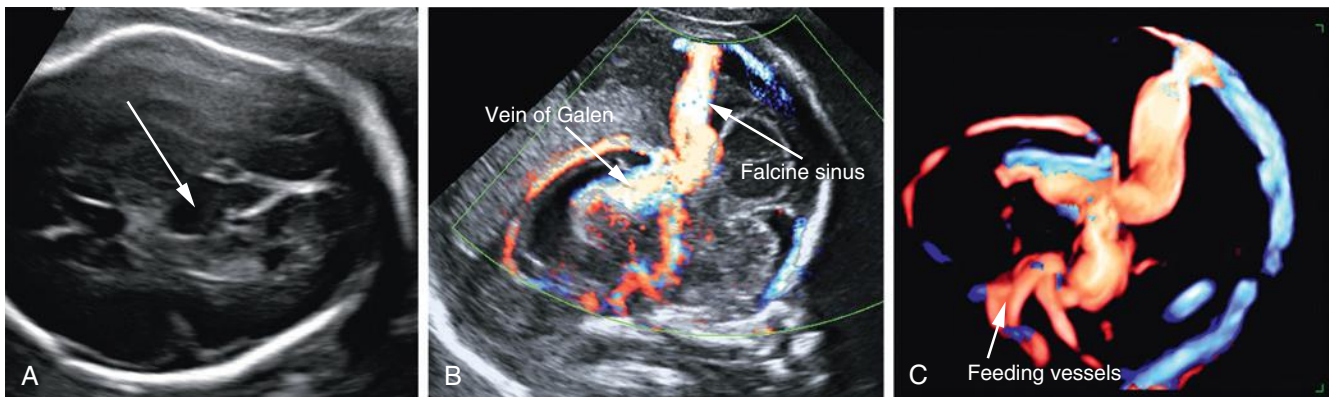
Aneurysm of the vein of Galen: A, The aneurysm appears as a hypoechoic tubular midline structure; B, with prominent turbulent intraluminal flow on color Doppler sonography, draining into a large falcine sinus; and C, 3D color Doppler sonogram delineating the vascular anatomy with abnormal arterial feeding vessels supplying the large vein of Galen.
